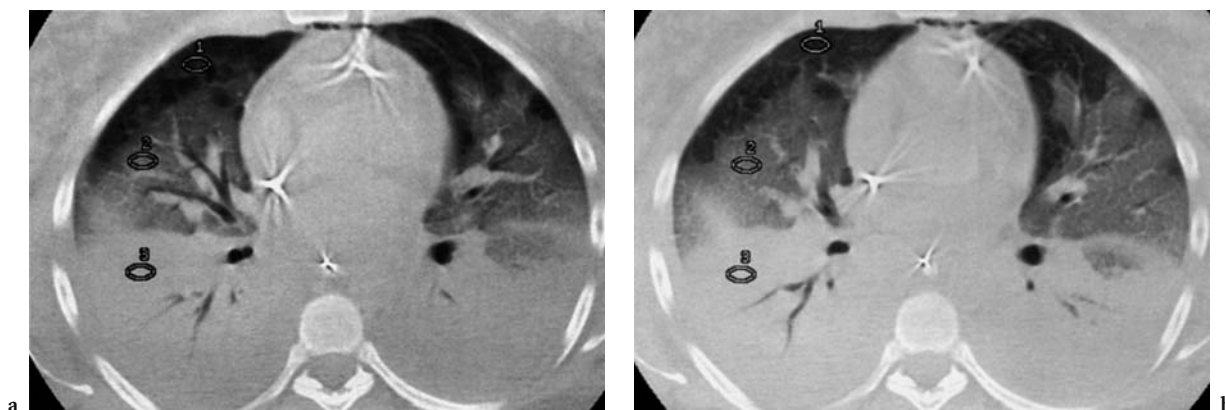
Fig. 8 PEEP effects - ARDS_{exp}. A Baseline expiratory CT. B During 10 cc H₂O PEEP, 700 ml tidal volume. Increased aeration most pronounced ventrally. Zone 1, diminished 124 Hu. Zone 2, diminished 66 Hu. Zone 3, diminished 15 Hu (GOODMAN 1996, with permission)
